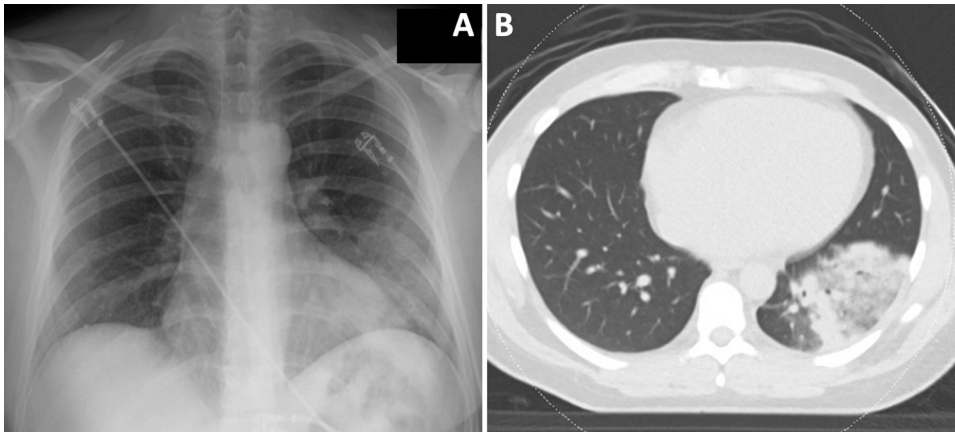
Chest Radiography. A. Opacity in lower left lung field on chest X-ray. B. Consolidation in left lower lobe on chest computed tomography.
